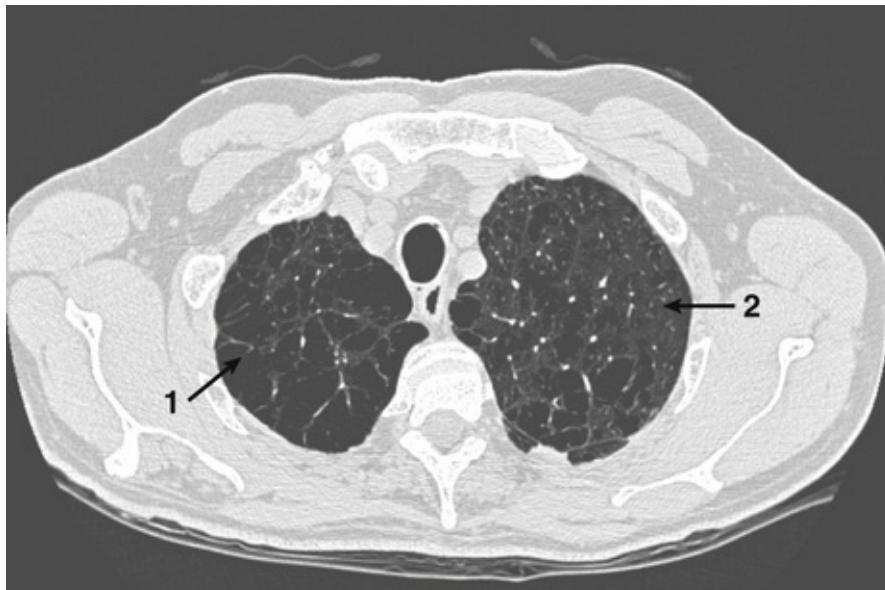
CT section of a patient with chronic obstructive pulmonary disease, which shows how the lung contains black holes (1) and thin thready blood vessels (2).
